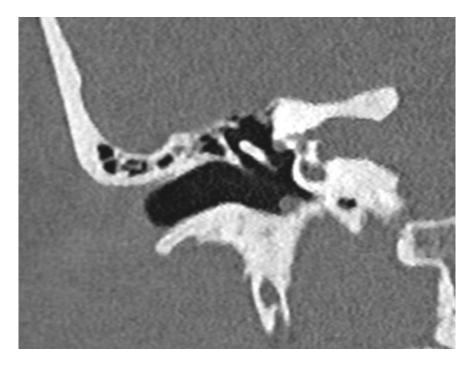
CT temporal bone coronal view showing small mass in the hypotympanum. (arrow)
